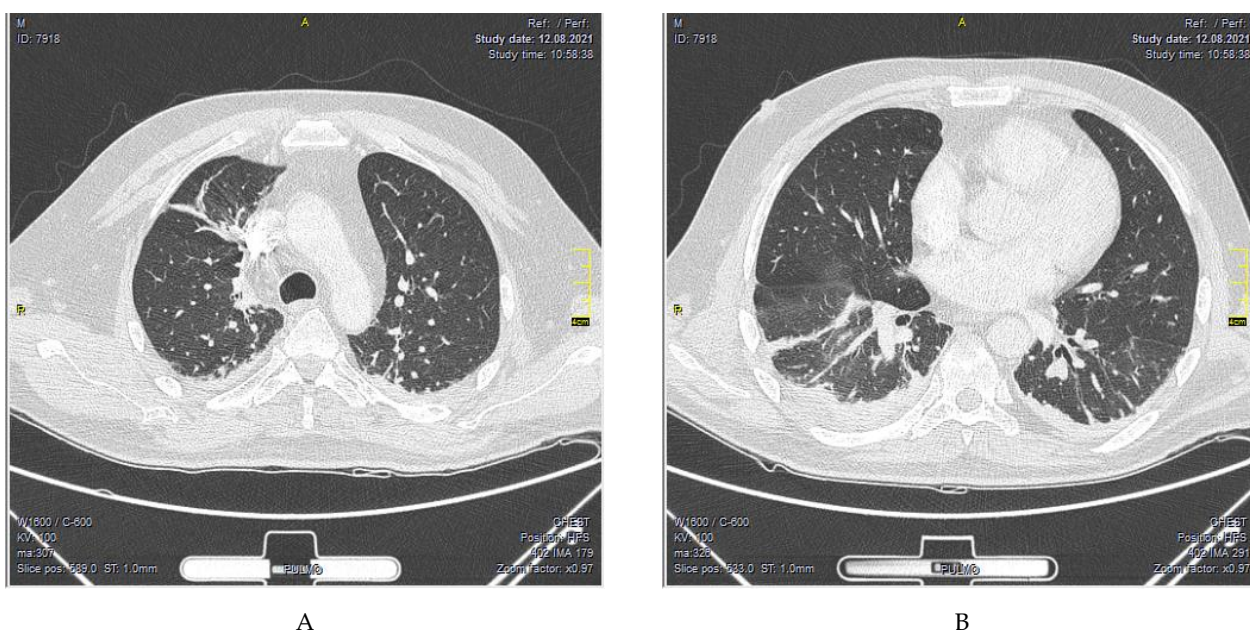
CT scan of the patient's lungs. a) fibroatelectasis is visualized in the upper lobe of the right lung; B) in the basal parts of both lungs, areas of consolidation, subsegmental atelectasis, and a trace amount of free fluid in the right pleural sinus are found
